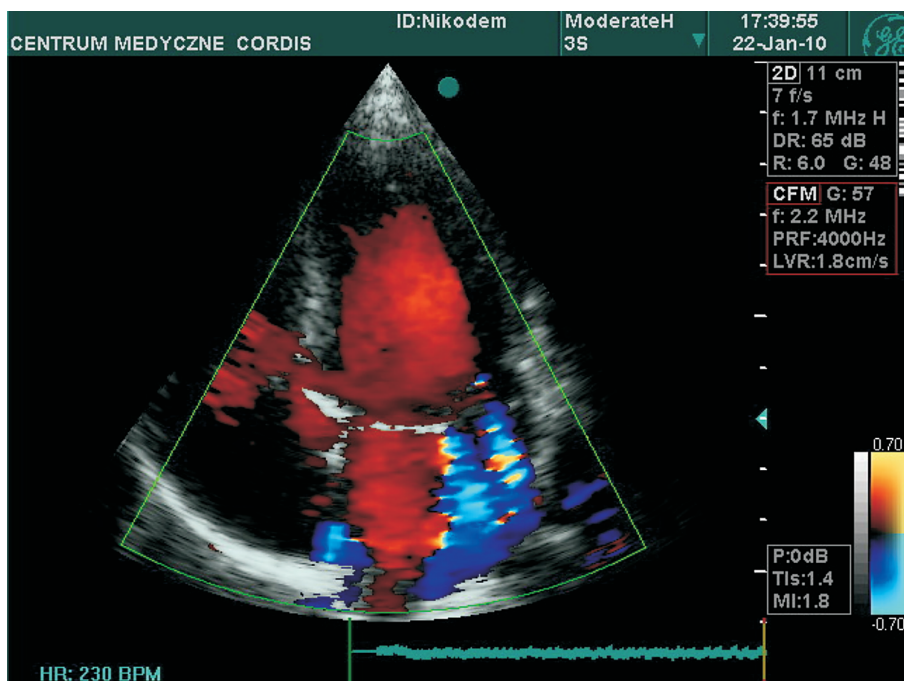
Echocardiography. Mitral valve prolapse (MVP) with mitral insufficiency (MI).
